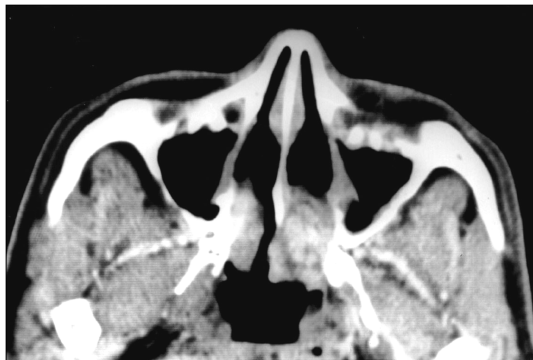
Axial computed tomography of paranasal sinuses showing a soft tissue density mass in the left nasal cavity.
